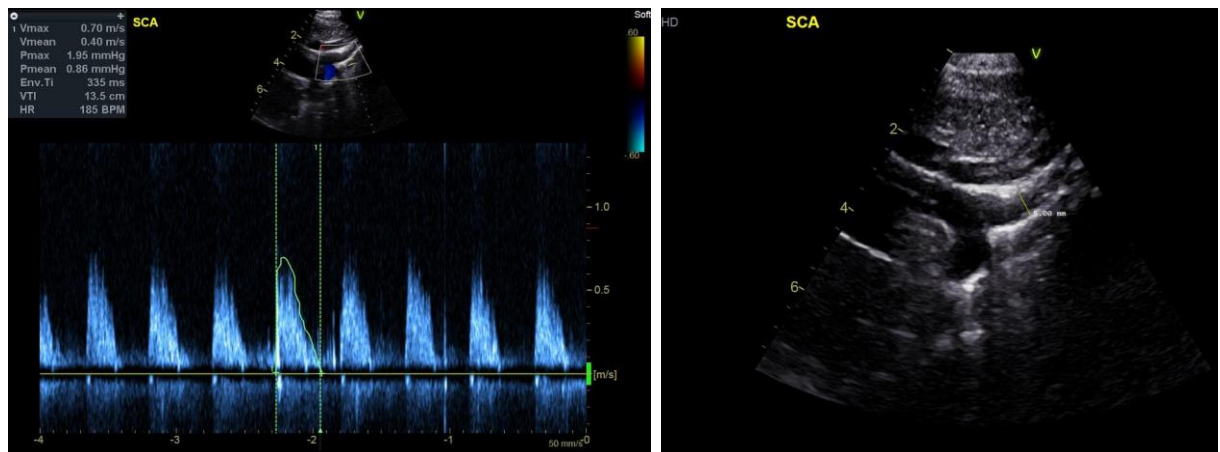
Left Subclavian echocardiography results from a pre-intervention investigation only as a post-intervention measurement was not possible.
